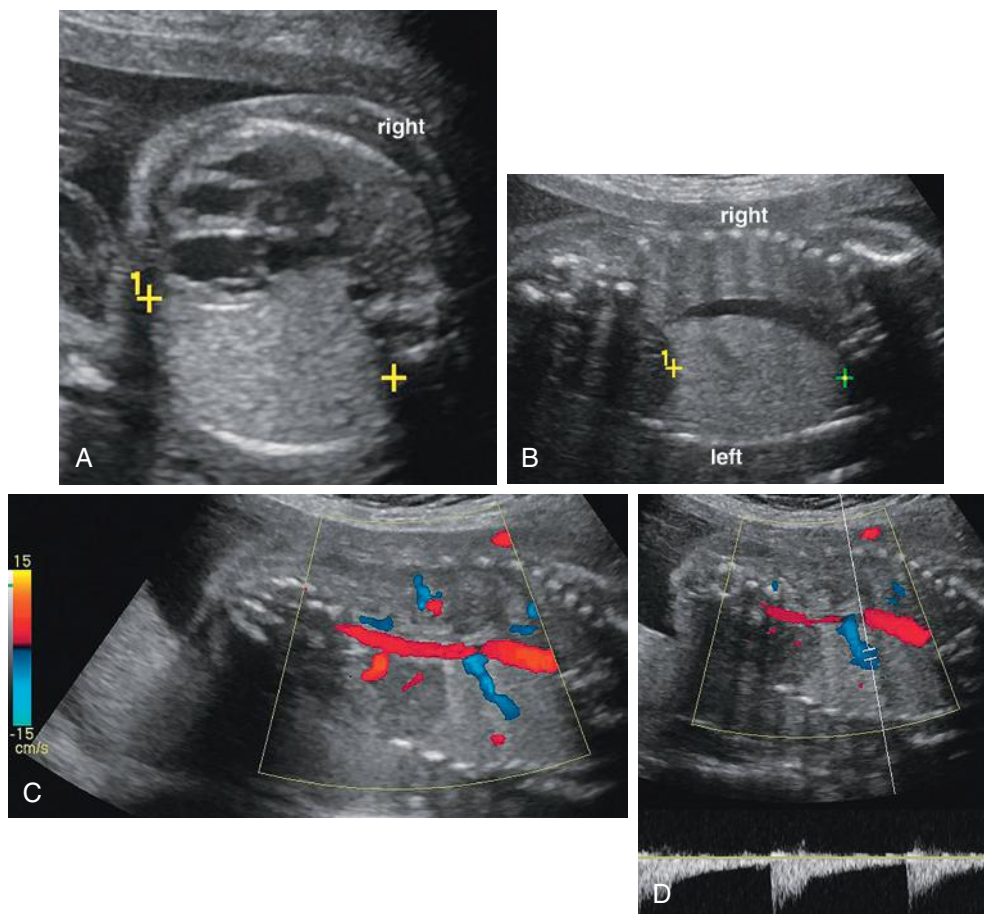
Axial (A) and coronal (B) views through the fetal chest with homogeneous left-sided mass consistent with bronchopulmonary sequestration (BPS). Note rightward cardiomeastinal shift. Color (C) and spectral (D) Doppler sonographic images of left-sided BPS demonstrating anomalous arterial supply to the lesion arising from the descending aorta.
